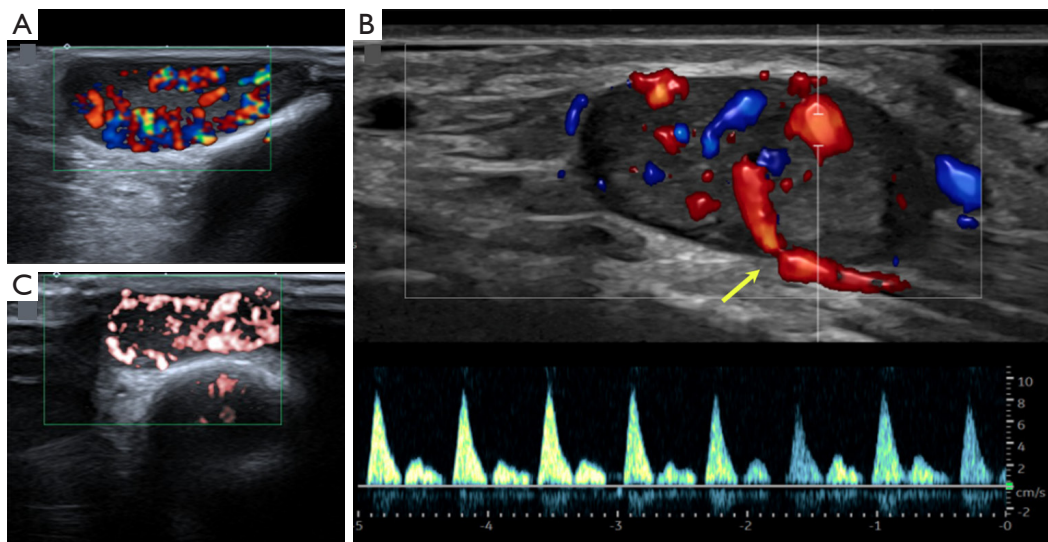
US Doppler typical angioleiomyoma pattern in three different patients: (A) female, 38 years old, toe angioleiomyoma; (B) male, 60 years old, hand angioleiomyoma, pulsed and color echo Doppler of the intratumoral vascular pattern with intense blood flow; (C) female, 53 years old, pulsed and color echo Doppler, longitudinal view of the hand, showing the typical vascular pattern with a feeding vessel (yellow arrow).
